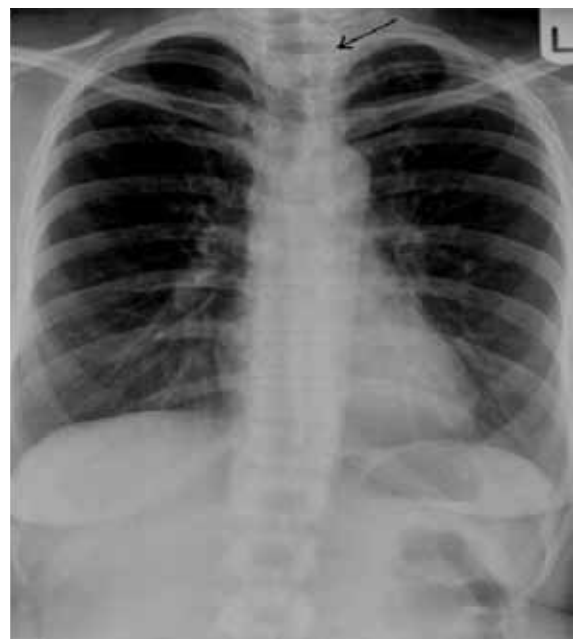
Chest roentgenogram shows a rounded opacity superimposed on the air-column of the mid-trachea (arrow).
